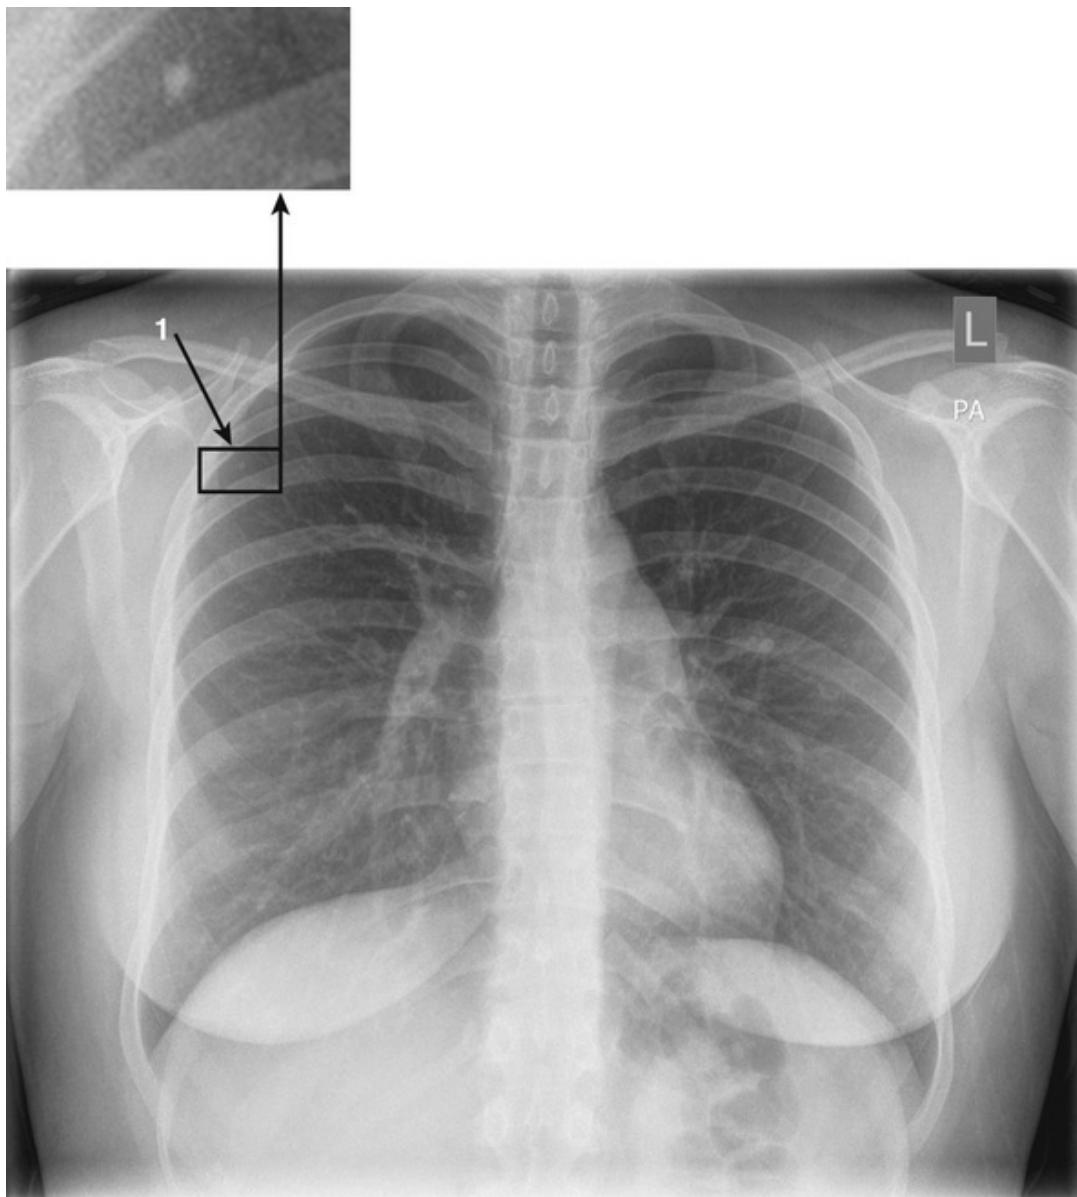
This is the chest x-ray of a 27-year-old lady with asthma. There is an incidental finding of a small granuloma (1) in the right apex. This is likely to result from previous tuberculosis infection, which, in this patient, as with many, was subclinical.
